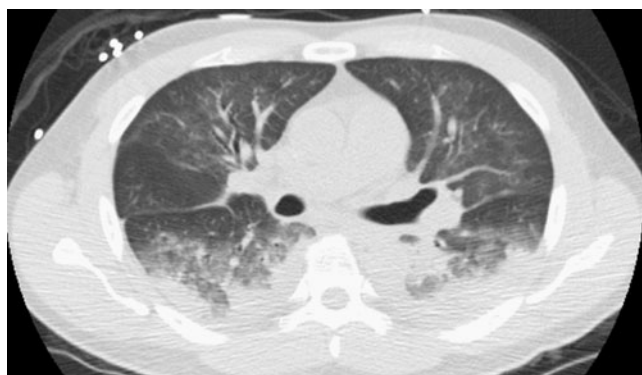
A 43-year-old man with novel influenza (H1N1) s/p autologous stem cell transplant. Axial CT demonstrates peripheral posterior bilateral lower lobe consolidation in addition to more diffuse ground glass opacity
